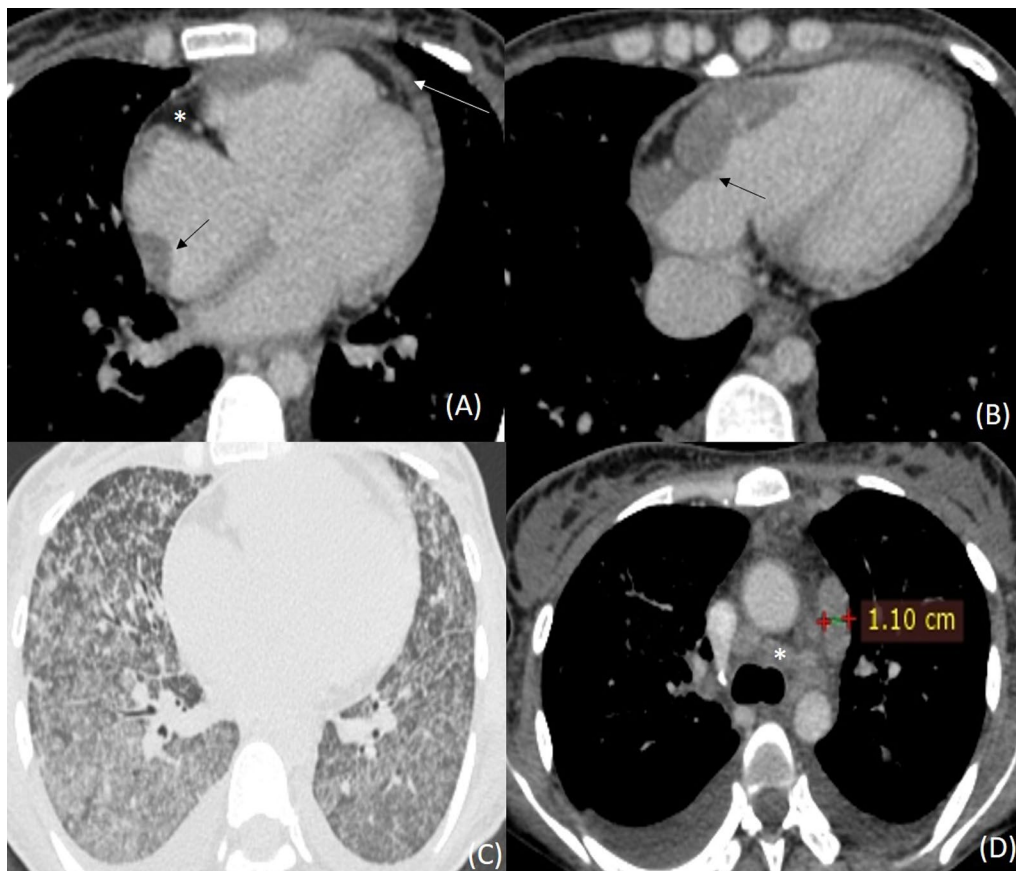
Cardiac tuberculosis with myocardial and pericardial involvement. CT images of a 42-year-old female show nodular thickening of the right atrial and ventricular myocardium (black arrow in A and B), thickening of pericardium (white arrow in A) and epicardial fat pad (* in A), lung window shows miliary nodules in bilateral lungs (C) and mediastinal window shows multiple enlarged mediastinal nodes (* in D) and bilateral pleural effusion (D)
